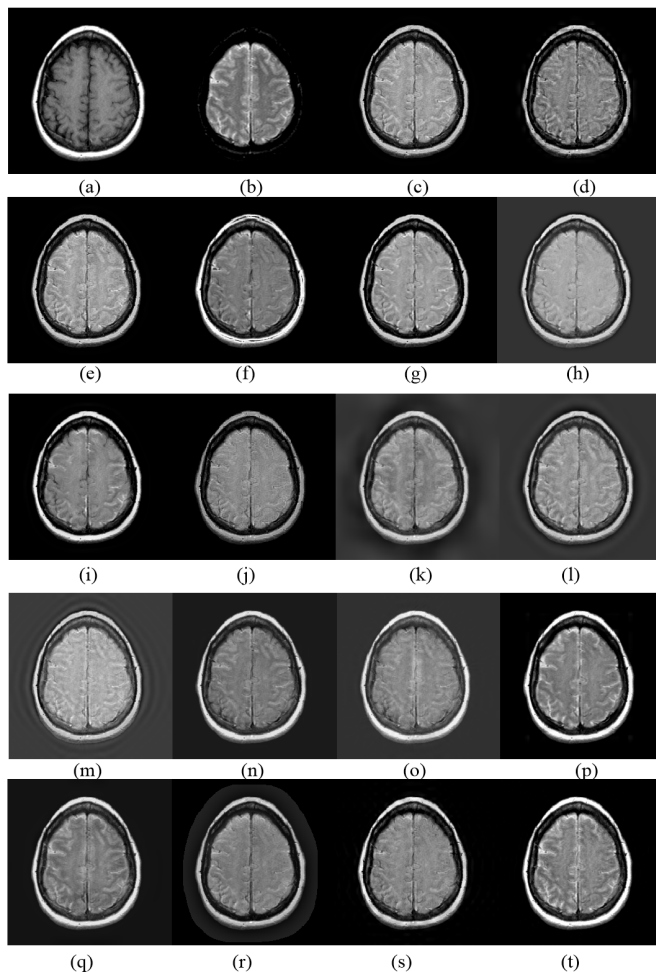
Experiments for S2. (a) CT. (b) MRI. (c) GP [52]. (d) DWT [52], [53]. (e) fsdP [52]. (f) GFS [54]. (g) CSR [55]. (h) ASR [56]. (i) GFF [57]. (j) MSVD [58]. (k) DTDWT [59]. (l) SWT [60], [61]. (m) CVT [62]. (n) DTCWT-SR [63]. (o) CVT-SR [63]. (p) LRSDL [64]. (q) PCLLE [65]. (r) MSGIF [66]. (s) DCHWT [67]. (t) Proposed.
